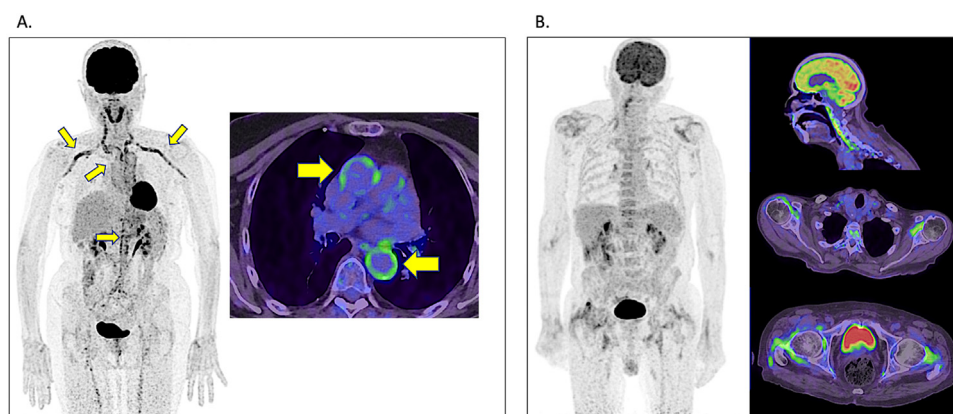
FDG-PET for the diagnosis of GCA, validated by EULAR. (A) In the case of typical clinical symptoms, primary diagnosis may be now confirmed by FDG-PET/CT, avoiding invasive biopsy. (B) In the case of atypical PMR presentations, FDG-PET is of relevance to rule-out GCA.
